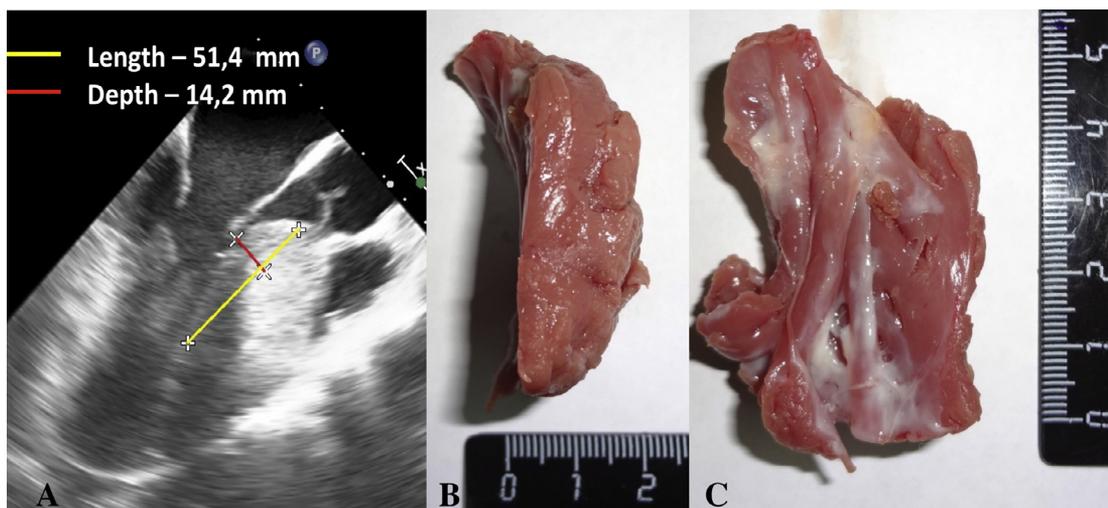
(a) Modeling of an adequate septal myectomy into the left ventricular outflow tract measured by intraoperative transesophageal echocardiography (long-axis view); (b) length and (c) depth of resected myocardium mass.
